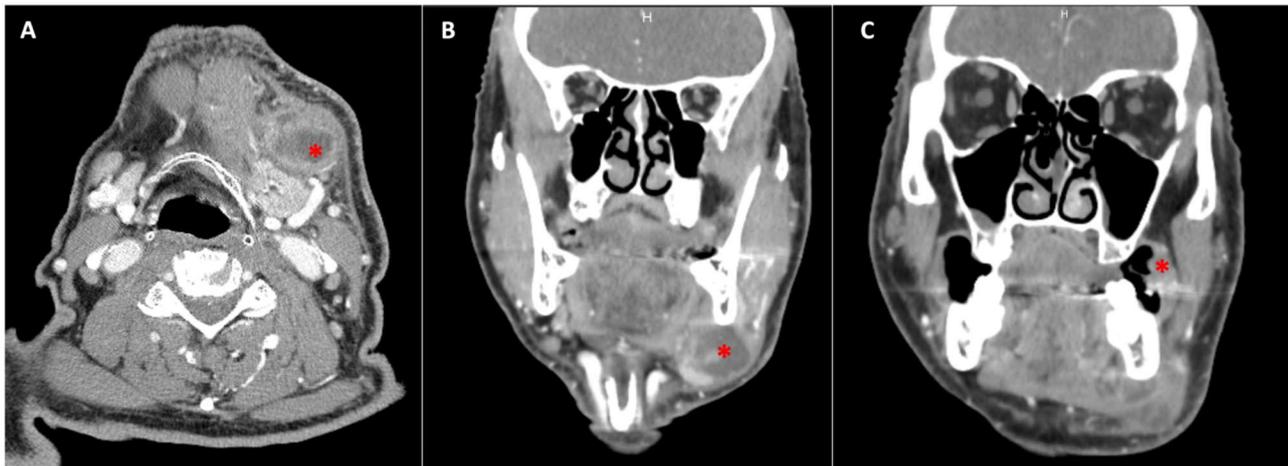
Pre-operative contrast-enhanced CT scan. A) Axial CT image with the adenopathy at the Ib level (*); B) Coronal CT image with the adenopathy at the Ib level (*); C) Coronal CT image with the superficial lesion of the left buccal mucosa (*)
